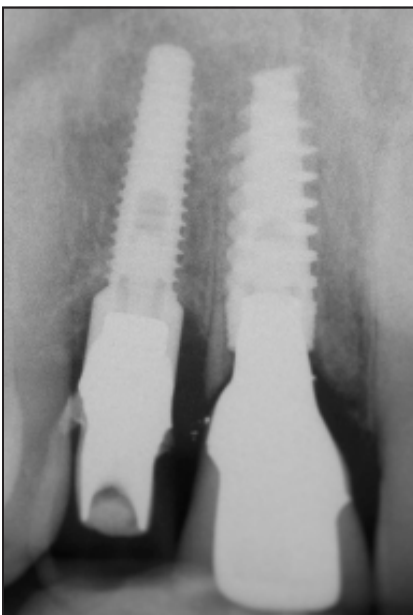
Periapical radiograph of the definitive restoration.
